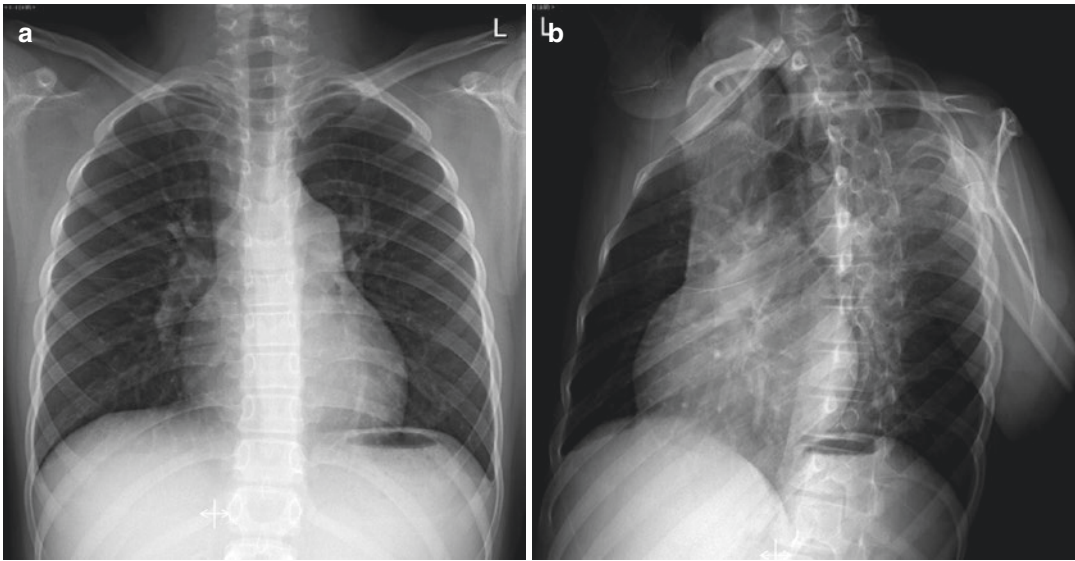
Pulmonary regurgitation in a 12-year-old boy with chest discomfort after exercise. Echocardiography shows pulmonary regurgitation, pulmonary hypertension and tricuspid valve regurgitation. Chest radiographs (a
